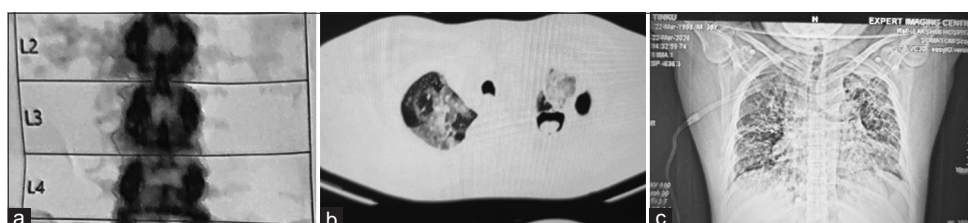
(a) Chest X-ray showing a mass-like opacity in the left upper zone; (b) high-resolution computed tomography of the chest; (c) dual-energy X-ray absorptiometry scan
